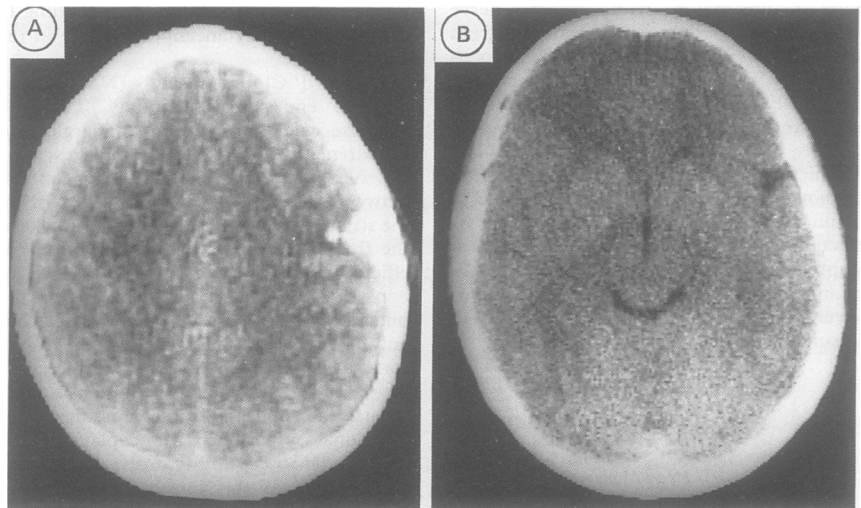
Figure a) Initial CT scan demonstrating small haemorrhage in the left fronto-parietal region; b) two years later, an area of focal cortical atrophy is seen at the site of the previous haematoma.
